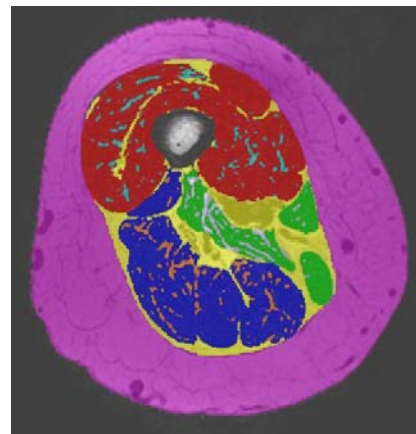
3T MRI fat-saturated image. Red=quadriceps muscle, blue=hamstrings muscle, cyan=quadriceps IMAT, orange=hamstrings IMAT.
